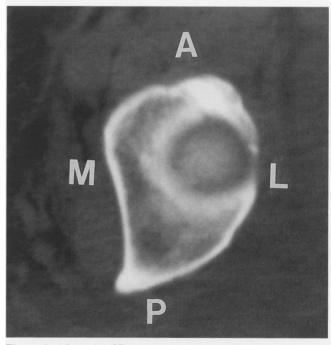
An axial CT cut at the level of the dome. Note the anterior, posterior, medial and lateral borders of the acetabular dome.
